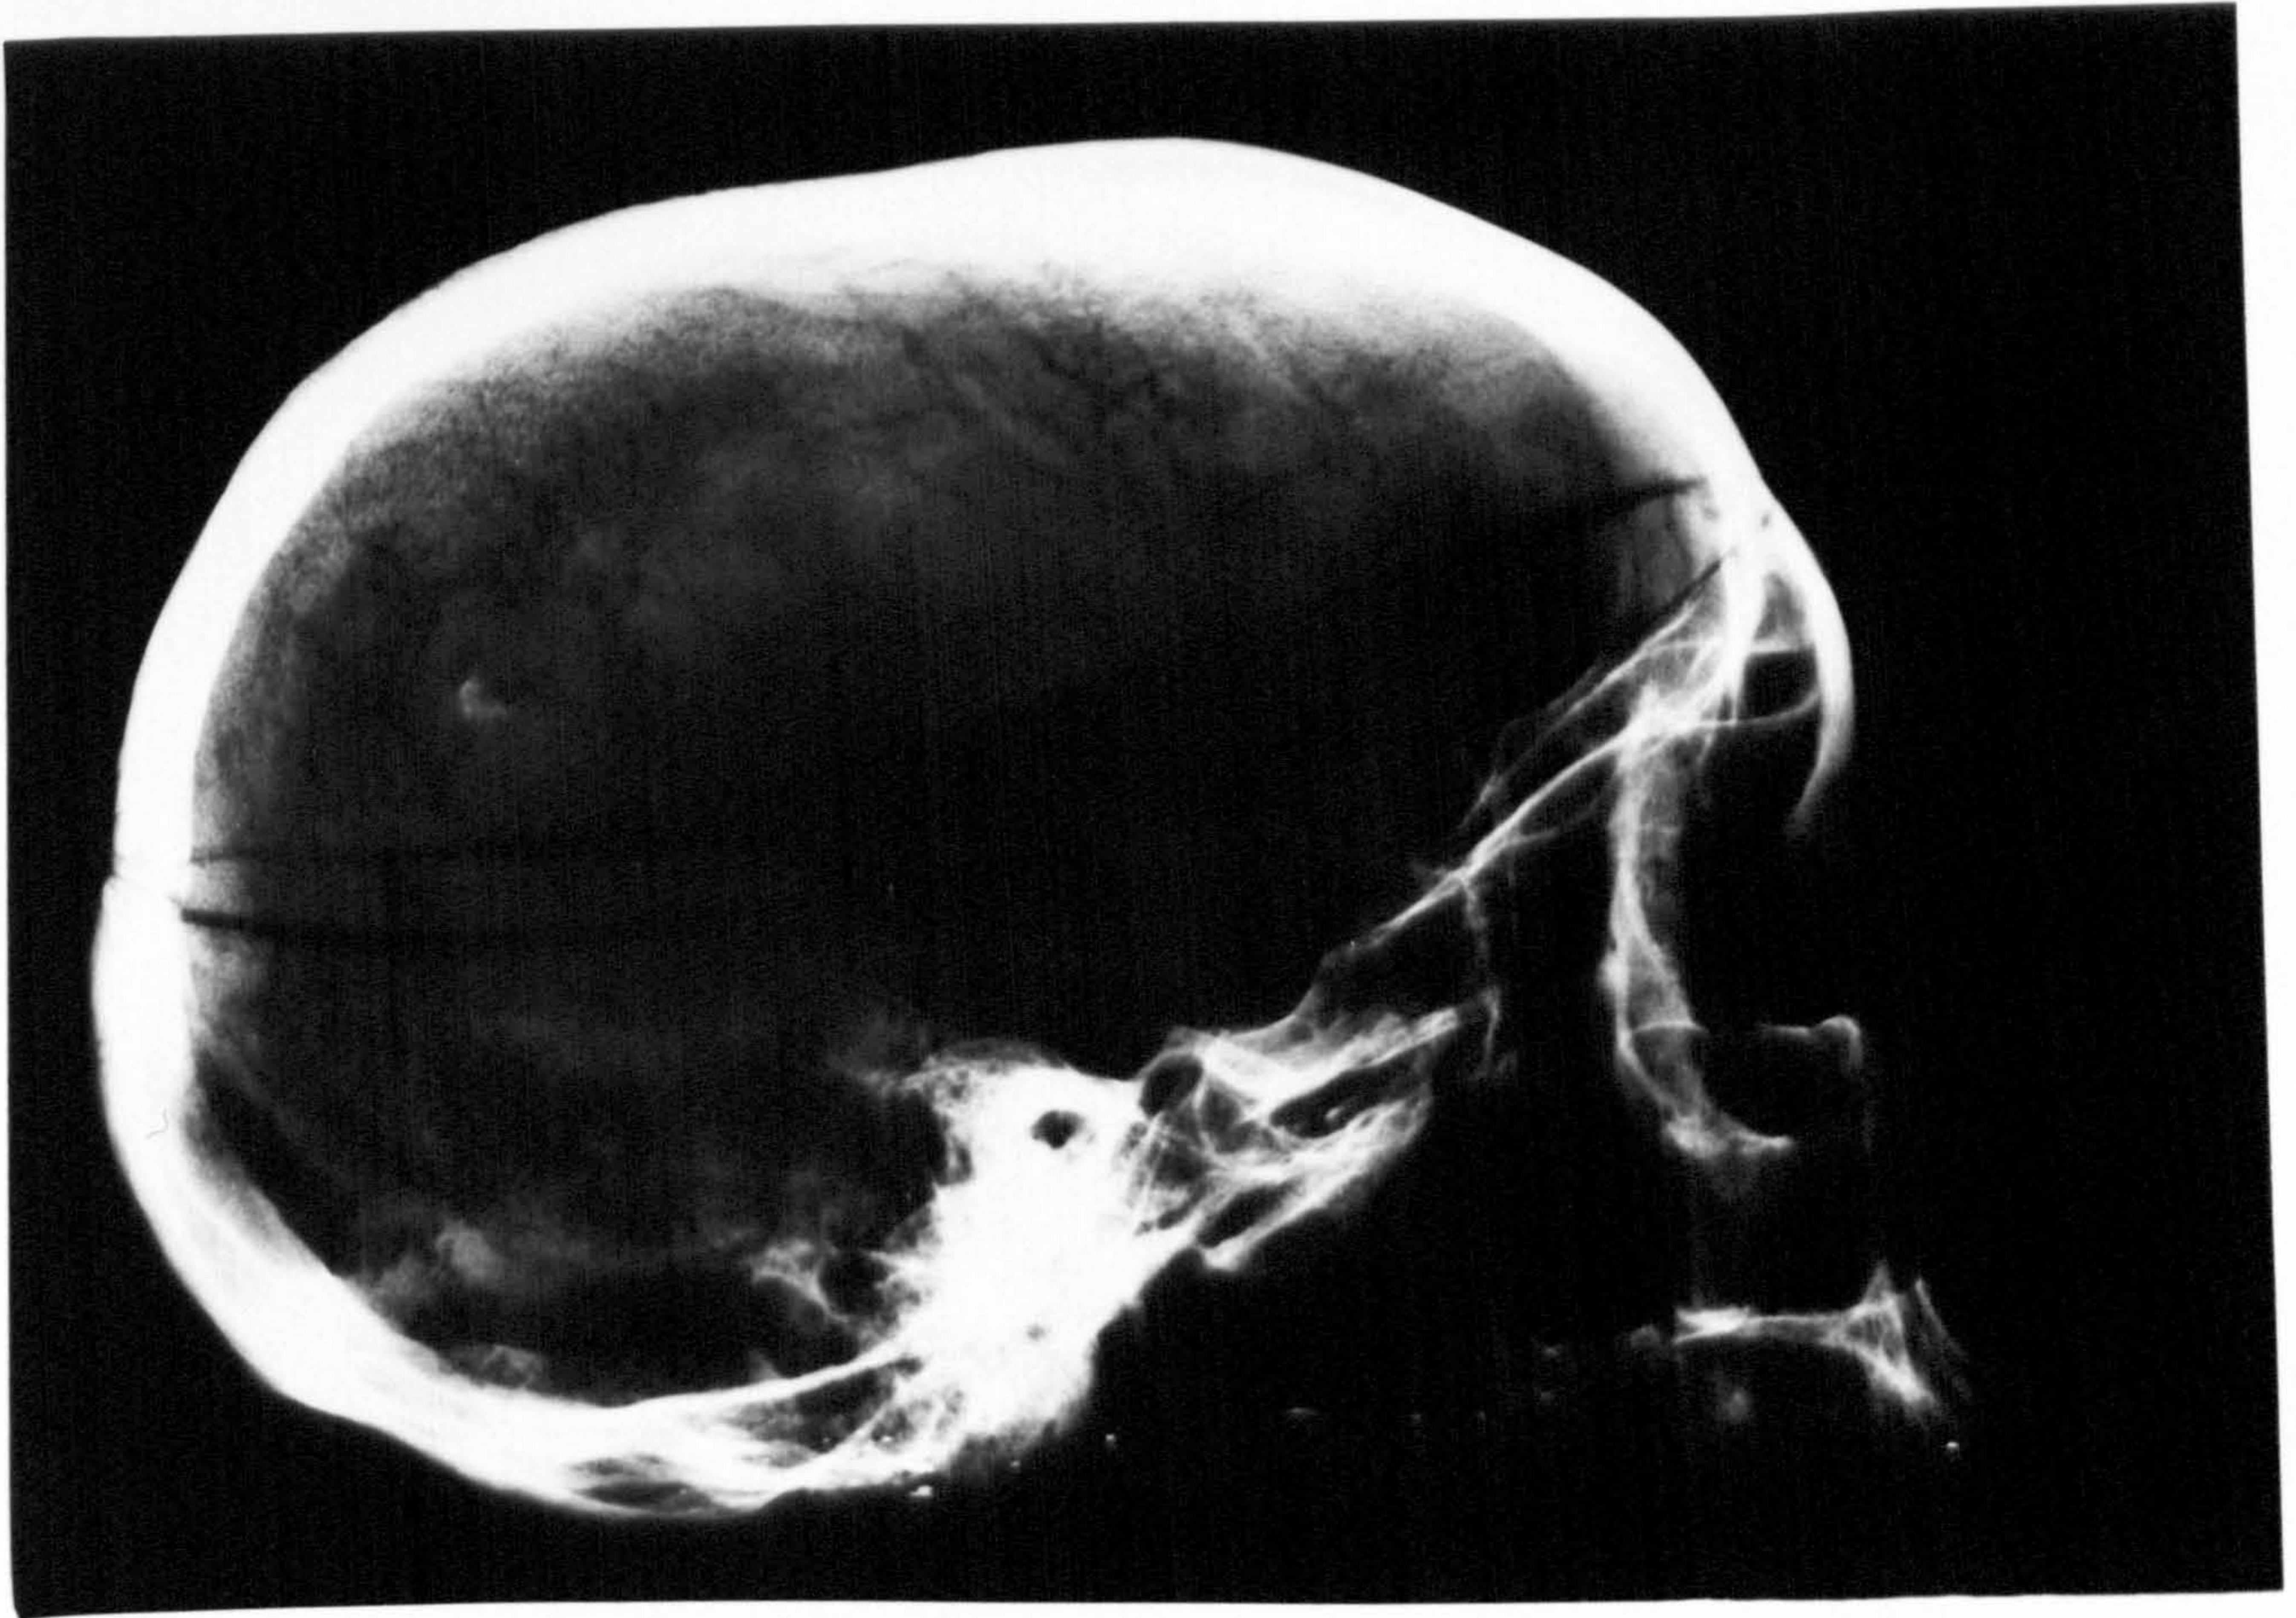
X-ray appearance and visual appearance of grade 1 HFI
